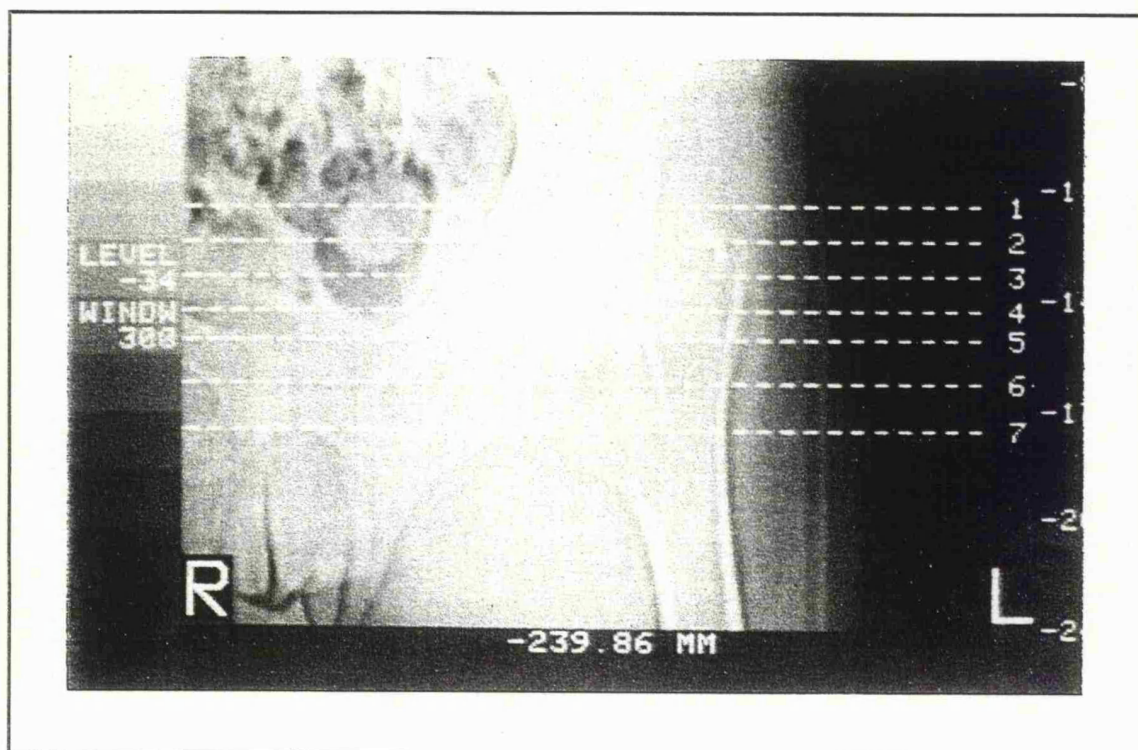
A CT scan of an undisplaced intracapsular proximal femoral fracture.
